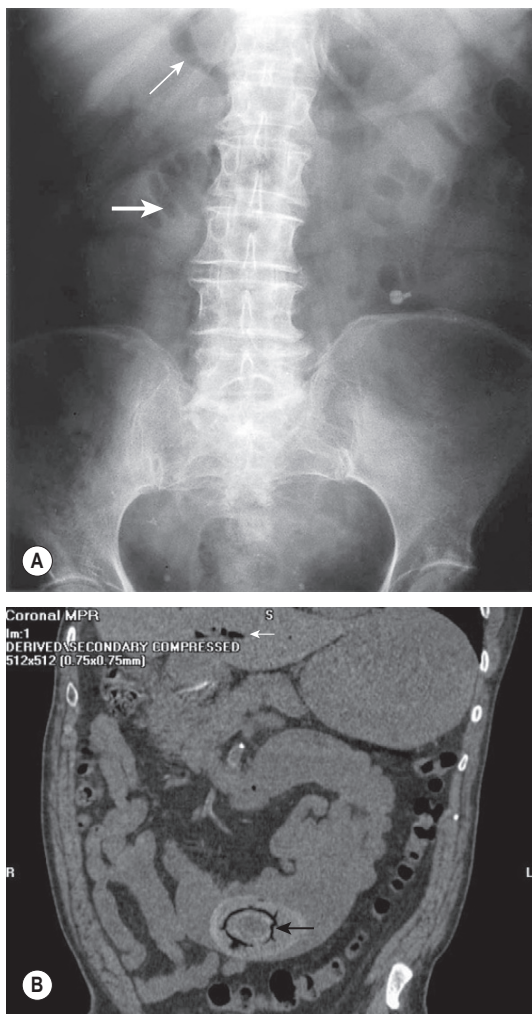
(A) Plain AXR showing gallstone ileus. In this case, a large non-radio-opaque stone was obstructing the upper jejunum. Only one small loop of distended bowel is seen in the abdomen (large arrow). Gas is clearly seen in the biliary tree (small arrow) indicating the presence of a cholecystoduodenal fistula. (B) CT abdomen showing gallstone ileus. A large gallstone (large arrow) is seen in a dilated loop of small bowel. Gas is seen in the intrahepatic biliary tree (small arrow).
